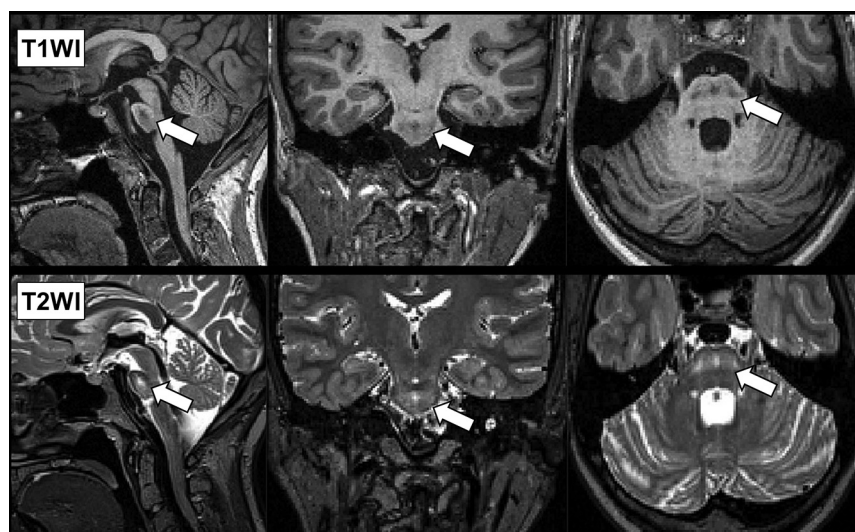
Sagittal, coronal, and axial MR images show pons signal abnormalities as T1 hypointensity and T2 hyperintensity in a patient with Wolfram syndrome (white arrows). Brain stem atrophy is also evident on this MR image.
